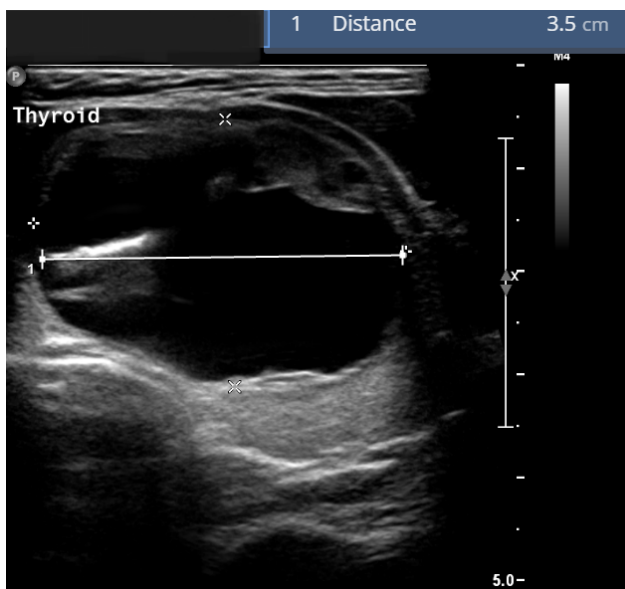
Ultrasound scan. An ultrasound scan showing a predominantly cystic nodule of the thyroid lobe measuring 3.5 cm, involving a septum and minimal solid tissue along the wall of the nodule.
